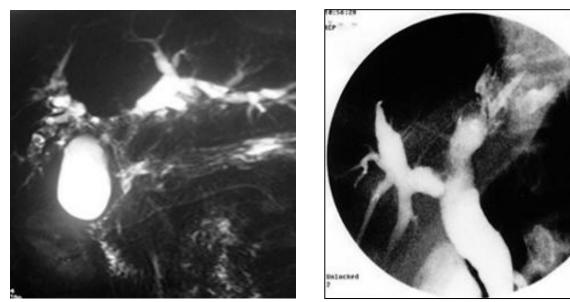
A 40 years old male had 2 episodes of cholangitis with ultrasound evidence of RPC.She underwent MRCP (A) which shows multiple stones in involving LHD and extensive disease in it's both segments with multiple stones and strictures. ERCP(B) done revealing stones in CBD, stricture in LHD with ENBD in place. Note at MRCP better visualization of major hepatic ducts and branches.
